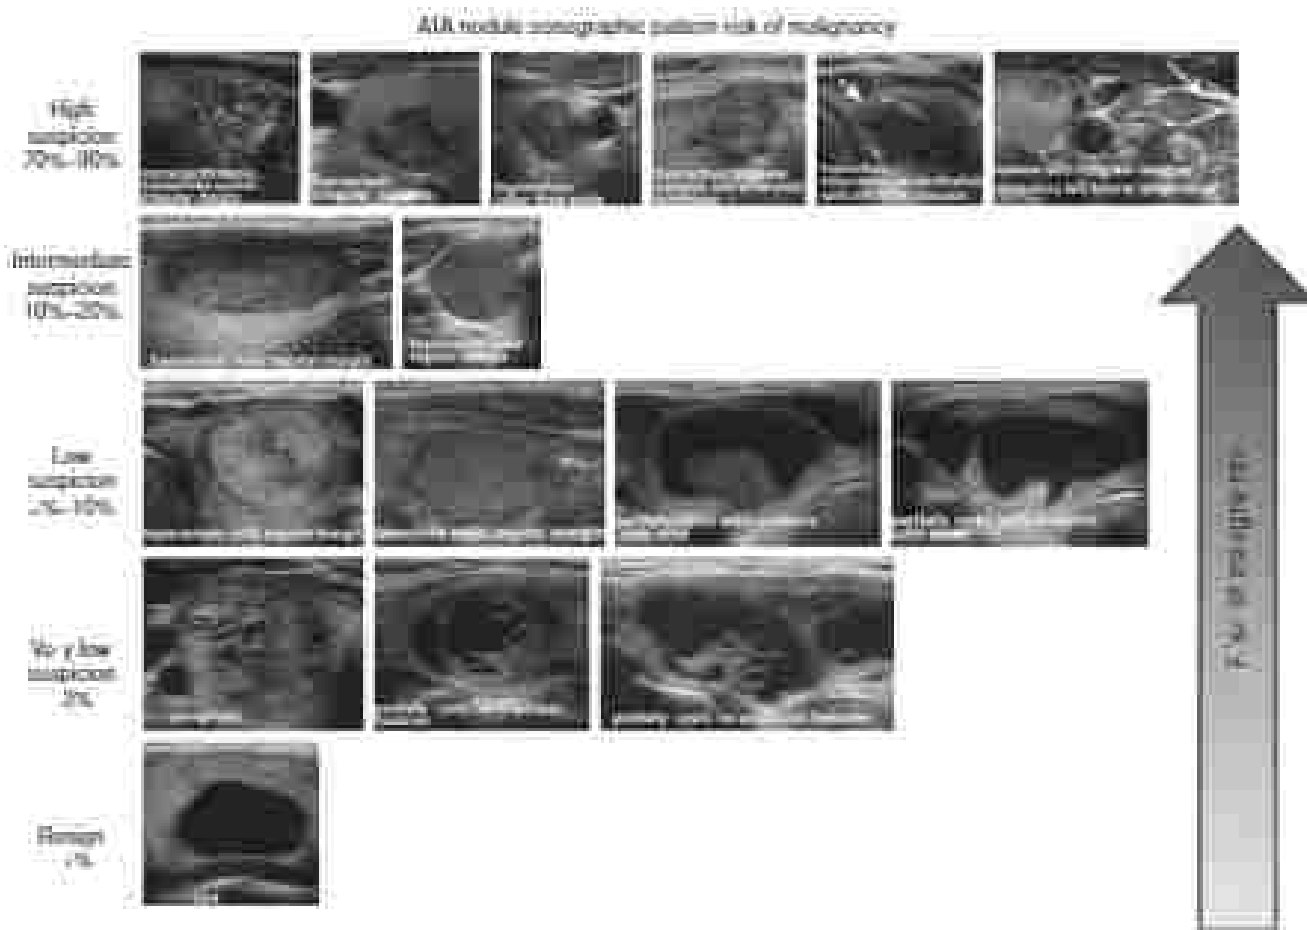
Sonographic findings are in risk stratification of thyroid nodules. (From: Hoque IM, Alexander EK, Miller AF, et al (2015) American Thyroid Association guidelines for management of thyroid nodules and differentiated thyroid cancer. *Thyroid* 25: 208-242.)
